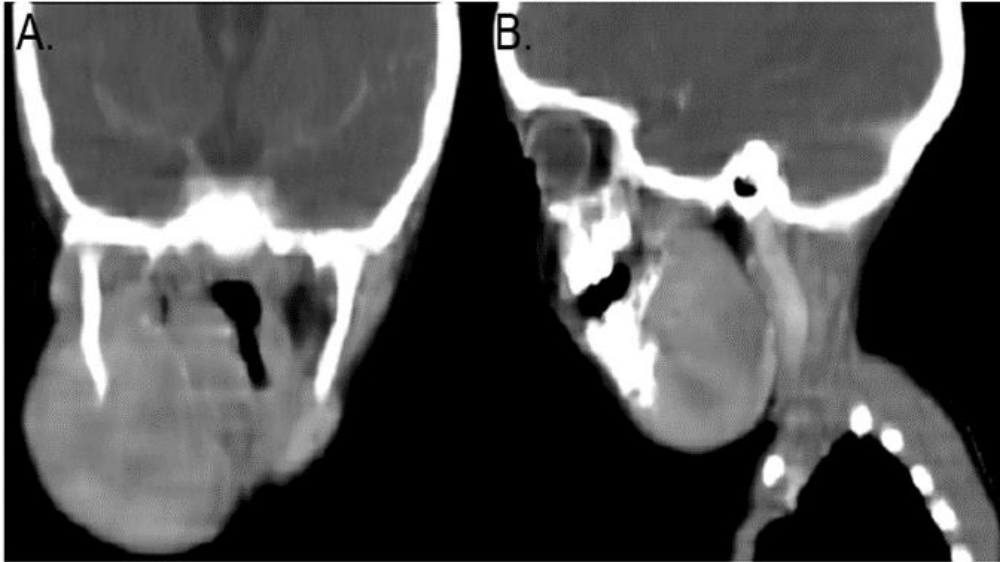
CT scan of the head showed an isodense mass on the right mandible.
